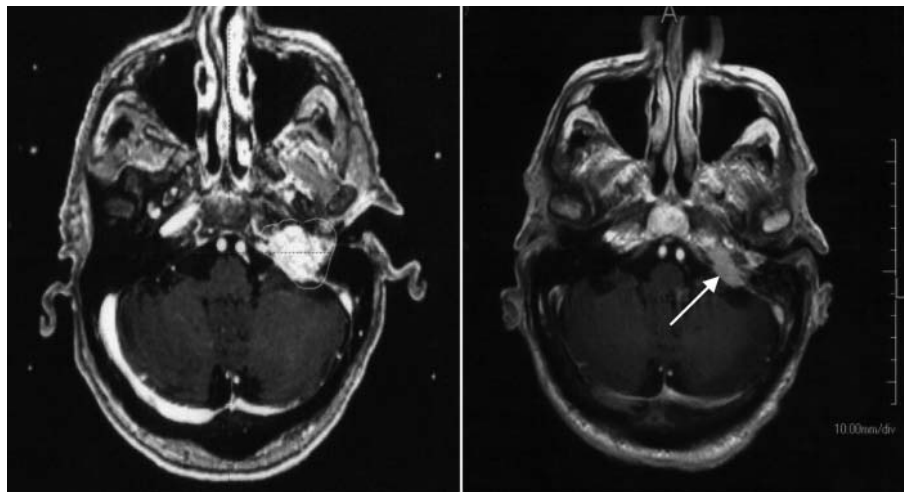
T1 gadolinium-enhanced images of glomus jugulare tumour in a 46-year-old patient (following resection) at time of GKR (left) and 7 months after GKR (right). Significant reduction in both tumour size and degree of radiographic enhancement are demonstrated (arrow)
